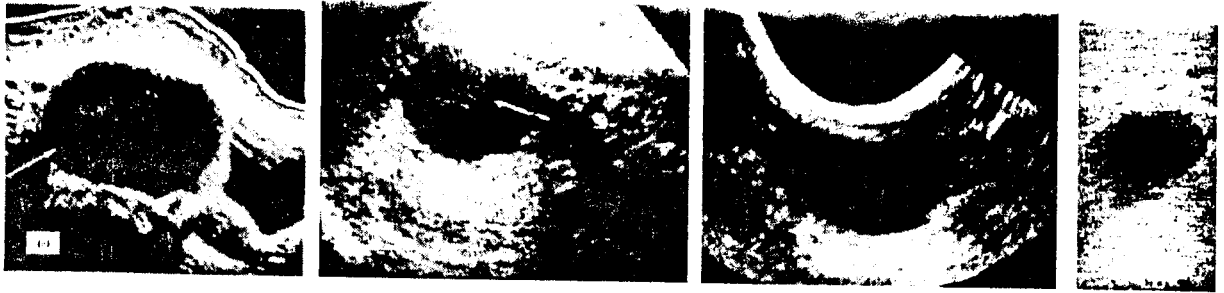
Liquid masses or Cysts : Anechoic masses which through-transmits ultrasound freely with indication of a distal bright up.
